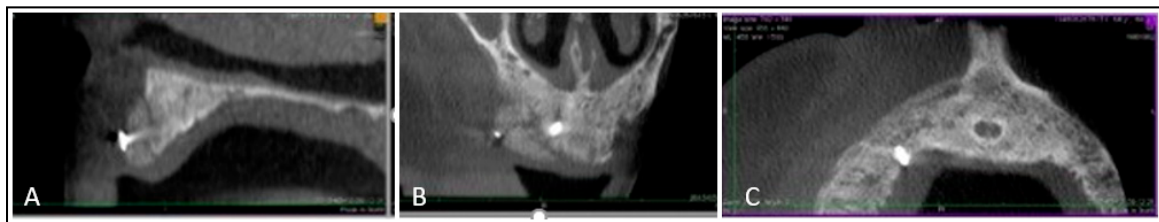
CBCT scan at 2 months after the surgical operation. It shows a good initial integration and stability of the SB[®] custom graft. (A) Sagittal view, (B) coronal view and (C) axial view.
